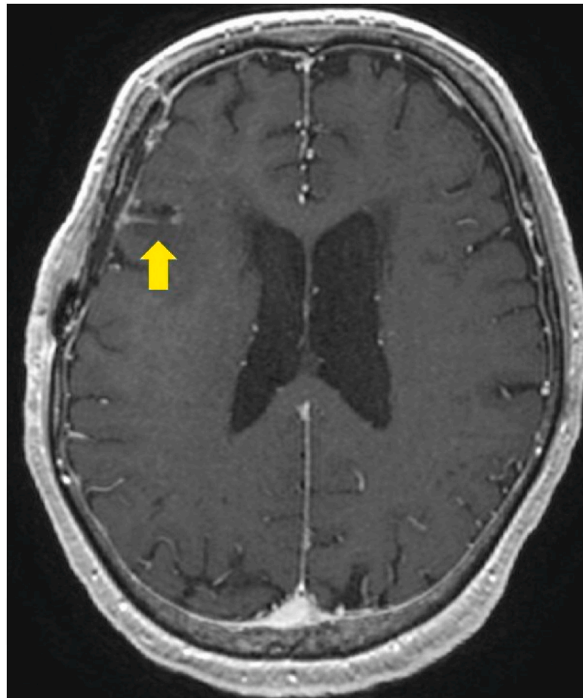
Brain magnetic resonance image showed that after metastasectomy and radiotherapy, the brain metastases disappeared and the surrounding edema improved.
